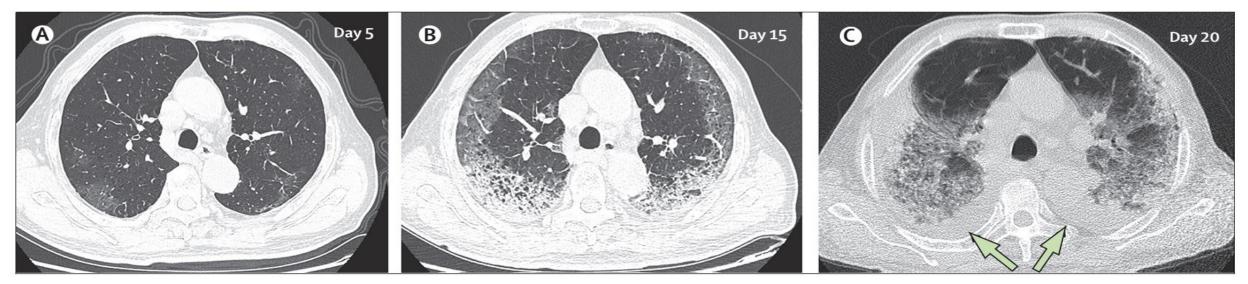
Transverse thin-section serial CT scans from a 77-year-old man
